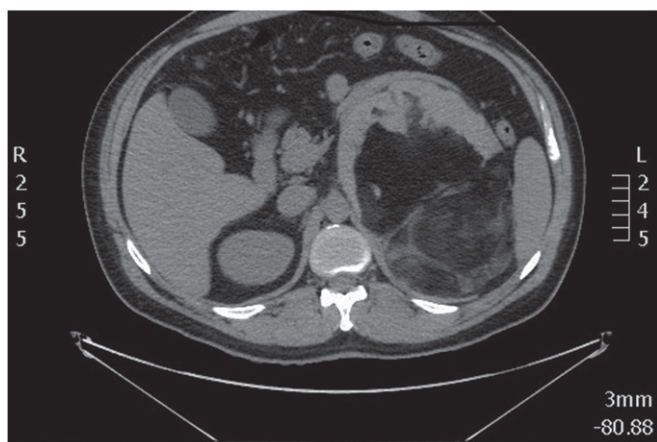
CT slice showing the mass.
